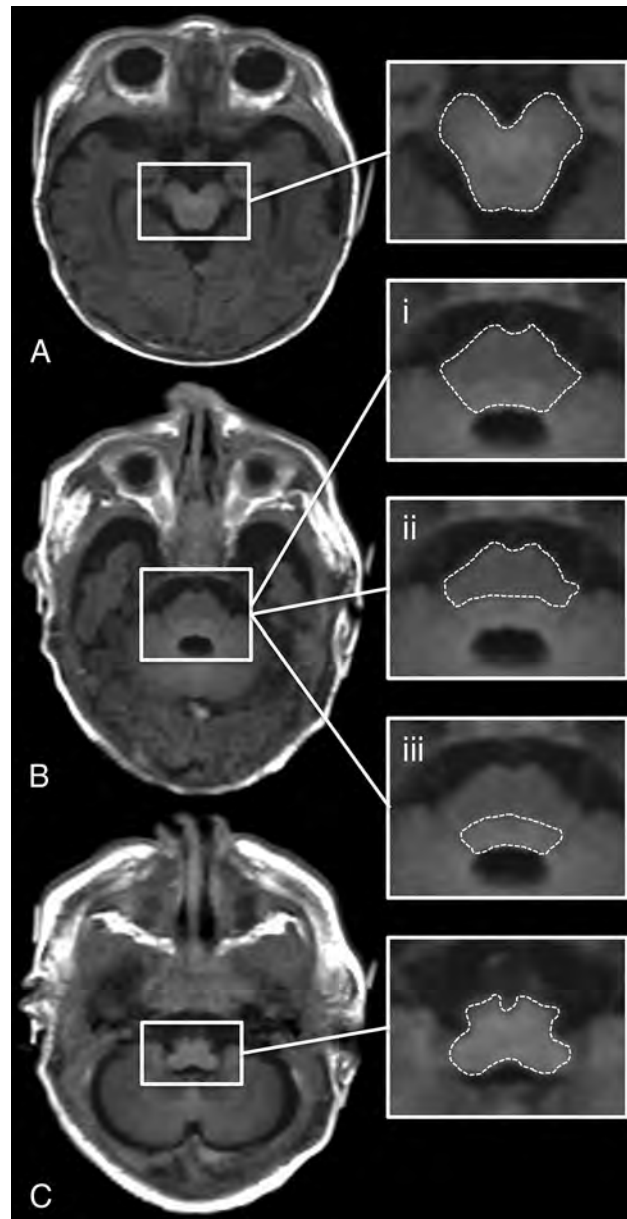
ROI placement is shown on an SyMRI-generated T1-weighted MR image (TR/TE = 650/10 ms) of a term-born neonate (GA: 40 + 1 weeks). A, Midbrain. B.i, Pons (basis pontis and tegmentum pontis included). B.ii, Basis pontis (tegmentum pontis excluded). B.iii, Tegmentum pontis (basis pontis excluded). C, Medulla oblongata.
